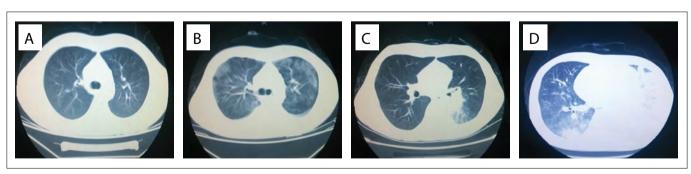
Chest computed tomography scans: A) There were no abnormal changes in the lungs prior to treatment (no pleural effusion and no infection); B) With the promyelocyte differentiation syndrome, computed tomography (CT) scans of the patient's chest showed groundglass opacity (GGO) in the two lung lobes and pleural effusion; C) After hormonal therapy, CT showed clear reduction of bilateral pleural effusion, such that the right side of the pleural effusion was basically absorbed. However, the lung consolidation with halo signs in the left pulmonary hilum means that fungal infection was likely; D) Massive pleural effusion was seen in the left lung, giving rise to pulmonary atelectasis, with patchy change in the right lung, when there was complete remission from acute promyelocytic leukemia (APL).
